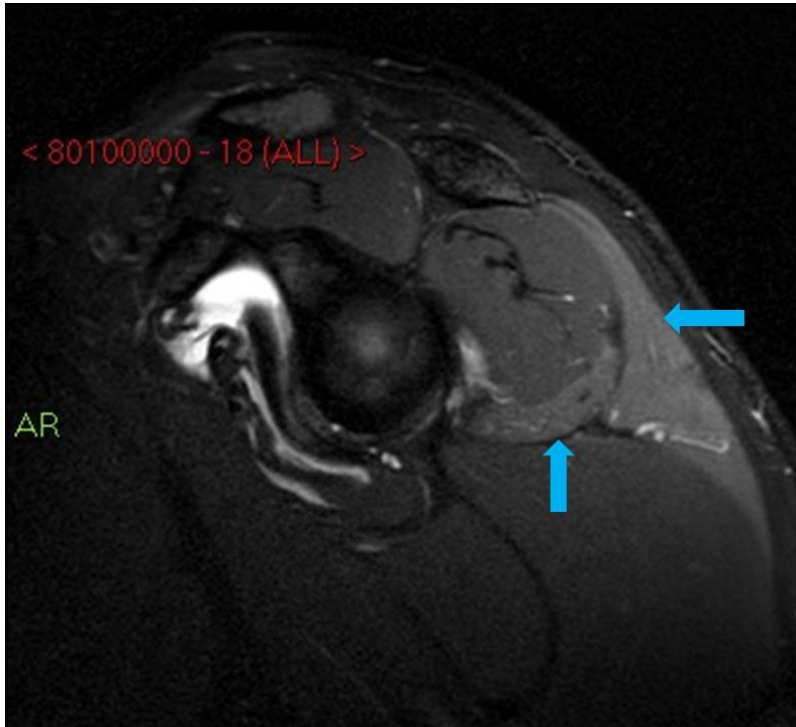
Sagittal T2 weighted magnetic resonance image of the shoulder showing increased signal in deltoid and teres minor as a result of axillary nerve injury.
